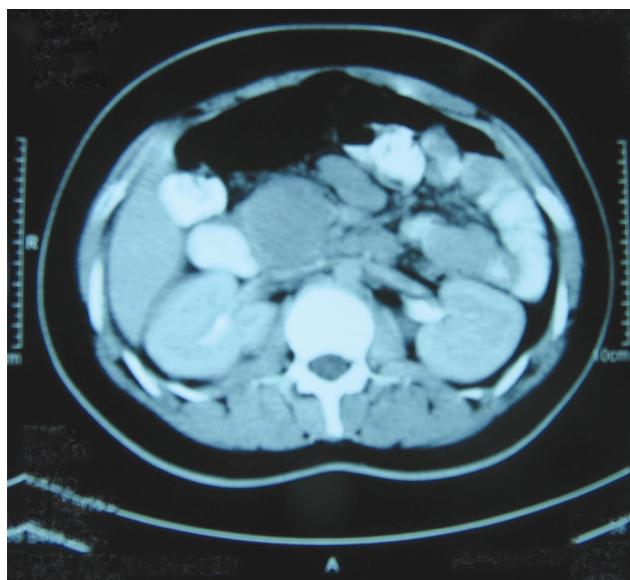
Abdominal CT showing a well-encapsulated lesion with solid and cystic components
